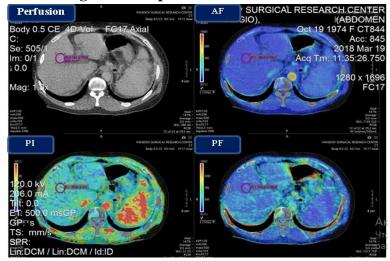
CT perfusion in liver cirrhosis.
